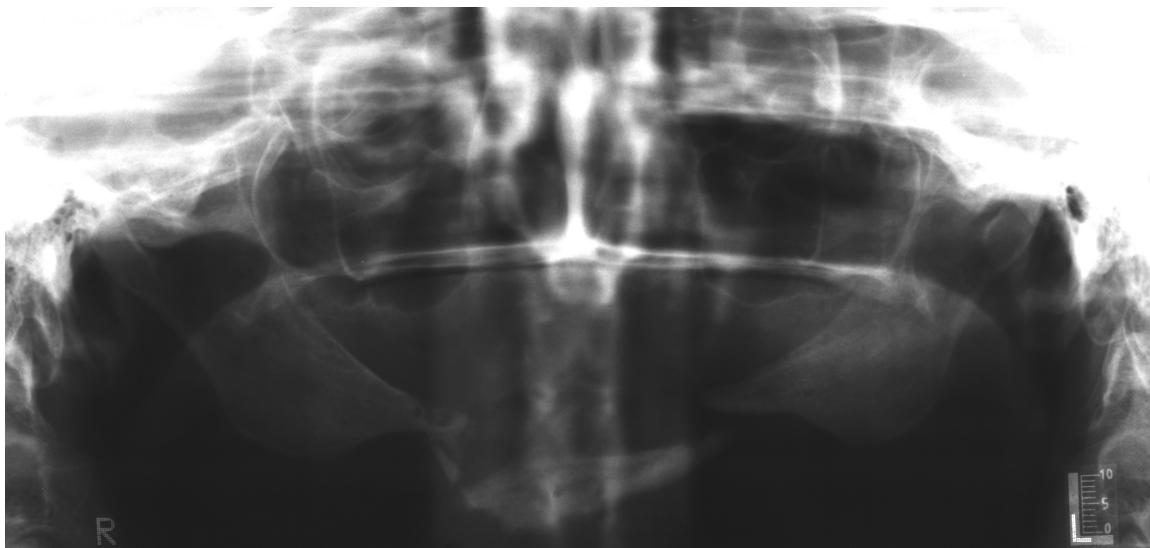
Panoramic radiograph of a patient with a fractured atrophic mandible (courtesy of Kamal Busaidy, D.D.S.).
